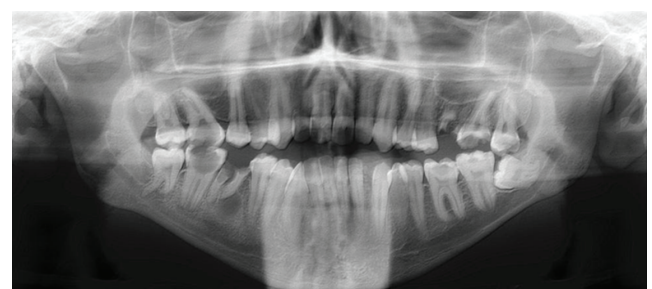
Radiographic examination, panoramic view shows no significant bony changes in the lesion area except a displacement of the teeth 33 and 32 away from the lesion.
